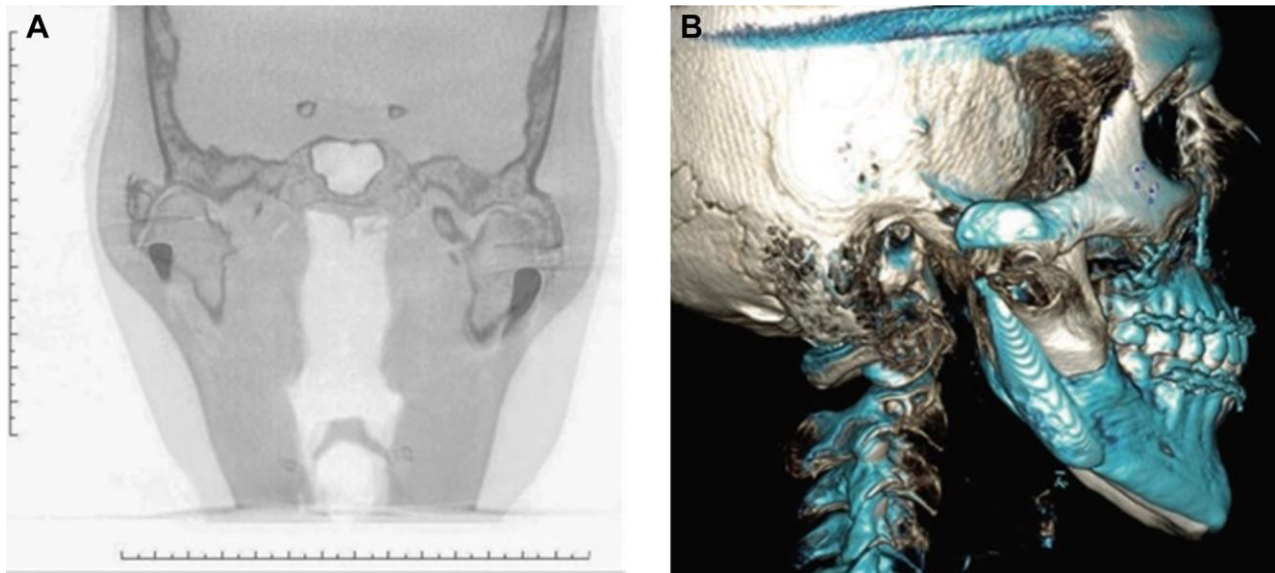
A, Computed tomography (CT). B, 3D CT image to correlate with navigation images. (Fig 57 continued on next page.)
